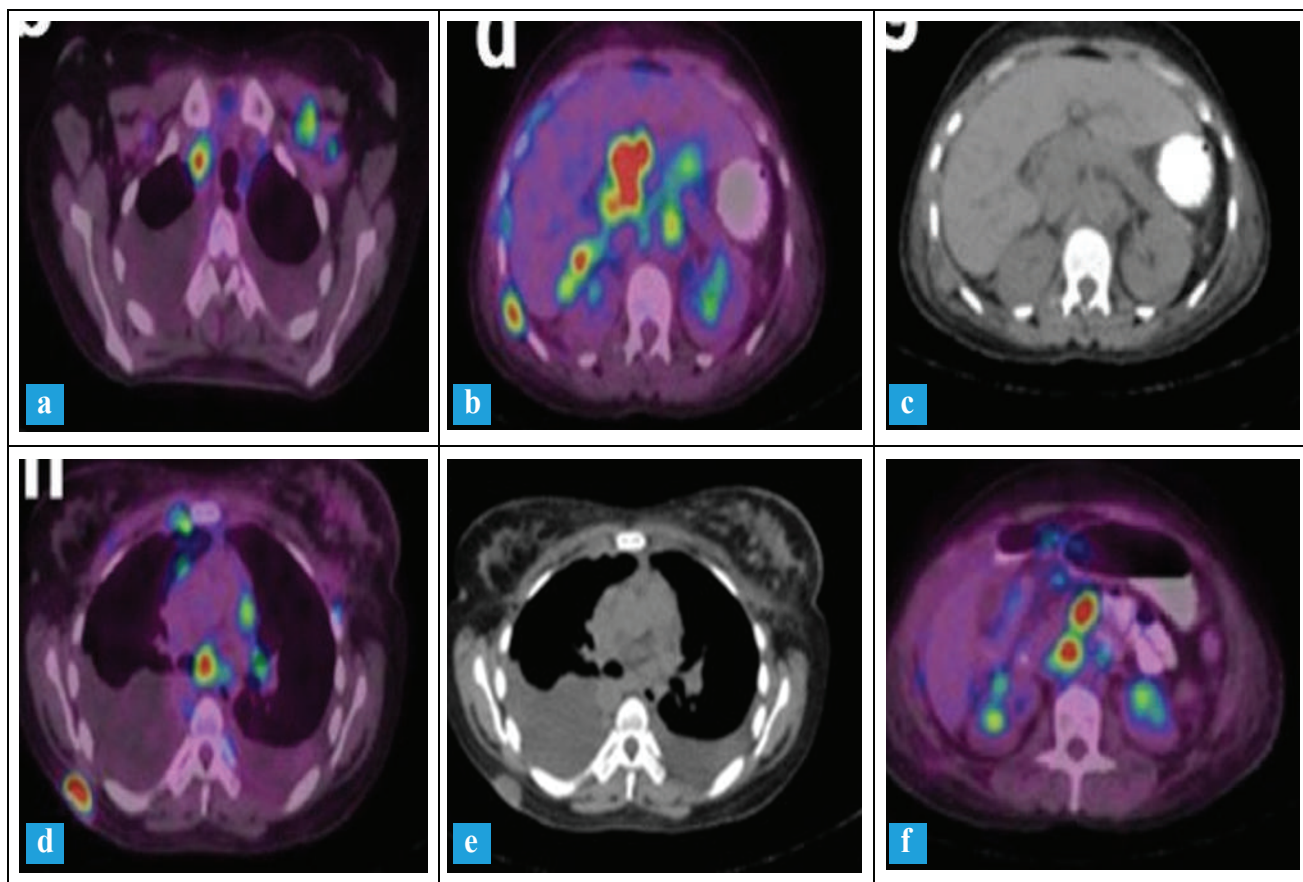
FDG PET-CT MIP image of a 28-year-old female patient two weeks after the first PET-CT scan; demonstrates metastatic right lower cervical (a) and abdominal lymph nodes (b) with metabolic progression. Metabolic progression of the prior intercostal nodule in the right tenth intercostal region (b) with a newly developed hypermetabolic subcutaneous nodule in the right posterior chest wall was also noted (c,d), bilateral moderate pleural effusions (d,e) were also evident. Newly developed metastatic hypermetabolic peritoneal deposits and hepatic metastases were also evident along with mild ascites (f).
